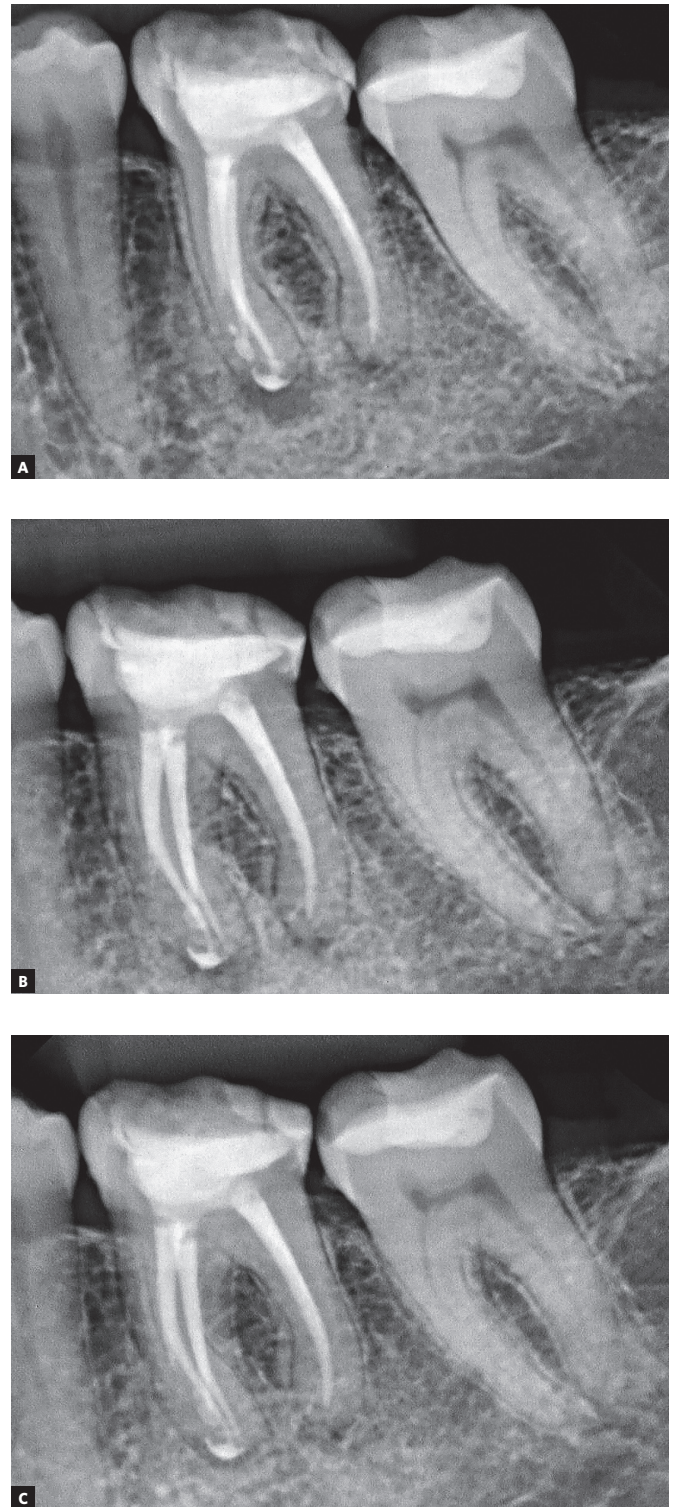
A) Radiography immediately after the endodontic treatment is completed and the perforation is filled with endodontic cement Endosequence® BC Sealer®. B) Radiograph 12 months after filling the root canal. C) Radiograph after 36 months. Radiographic image suggesting apical repair.
